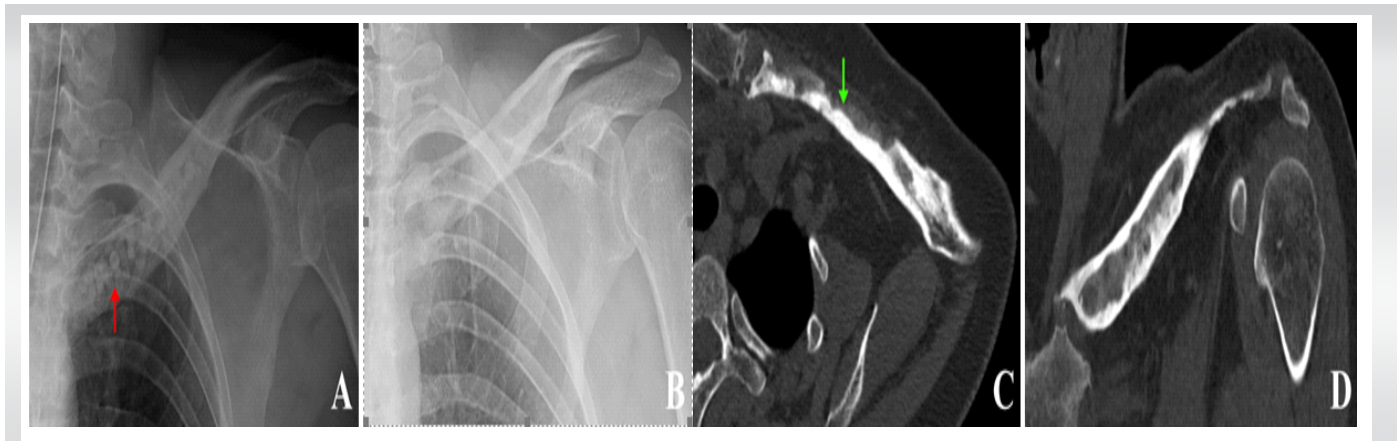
Post-operative X-ray and computed tomography (CT) scan images. (A) X-ray showing bone filling with calcium sulfate beads (red arrow). (B) X-ray at 2 months postoperatively showing resorption of the calcium sulfate beads. (C) CT scan at 3 months postoperatively showing anterior corticotomy of the anteromedial half of the clavicle (green arrow) in axial (C) and coronal (D) views.
